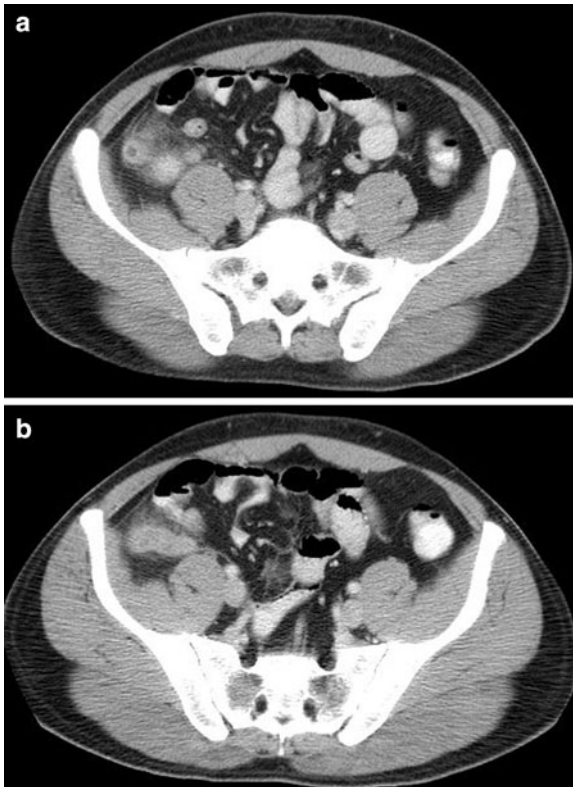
Colonic-type adenocarcinoma of the appendix presenting as acute appendicitis. Contrast-enhanced CT images (a) and (b) show the typical changes of acute appendicitis including a dilated, thick-walled appendix and stranding within the surrounding fat. Note however the increased soft-tissue at the distal appendix. Colonic-type adenocarcinoma with periappendiceal infiltration was confirmed at pathology
